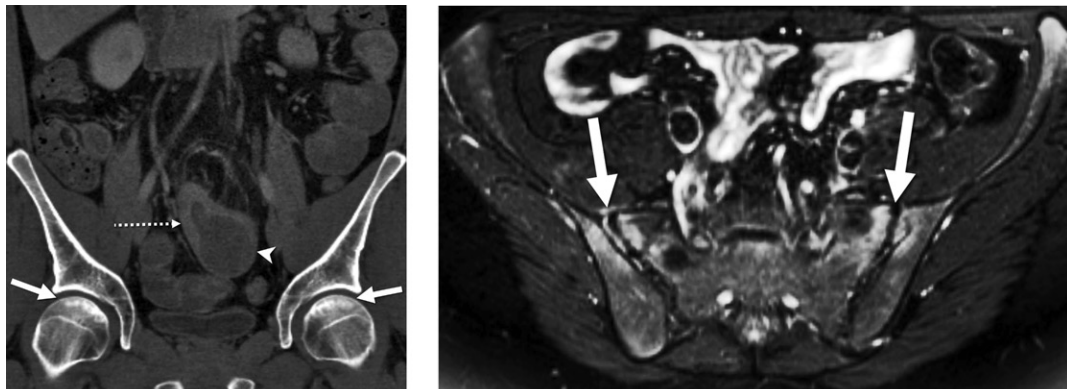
Bone complications in two patients with Crohn disease. (a) Coronal contrast-enhanced CT enterographic image (bone window) with neutral oral contrast material shows crescent-shaped areas of subchondral sclerosis in the femoral heads (solid arrows), findings consistent with bilateral femoral head avascular necrosis. Not as well visualized on this bone window image is small bowel wall thickening (dashed arrow) and upstream small bowel dilation (arrowhead), findings consistent with a stricture with active inflammation. (b) Axial fat-suppressed T2-weighted MR enterographic image with biphasic oral contrast material shows edema within and on both sides of the sacroiliac joints (arrows), consistent with bilateral sacroiliitis.
